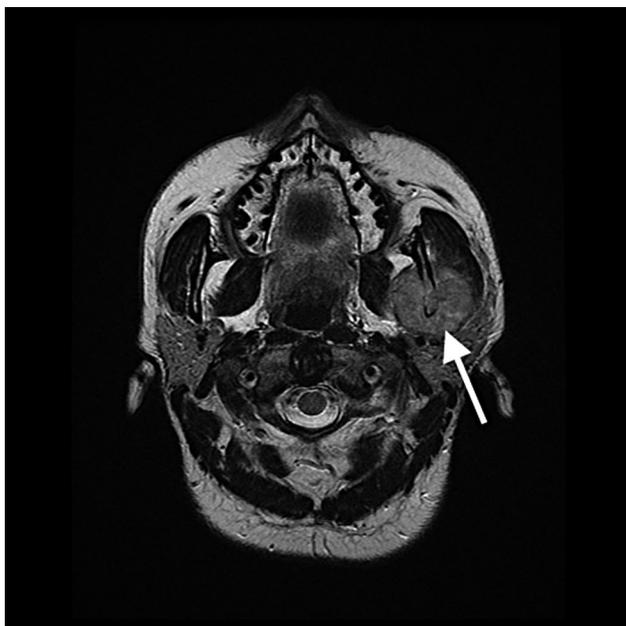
Axial MRI scan showing the left mandibular metastasis (white arrow).
